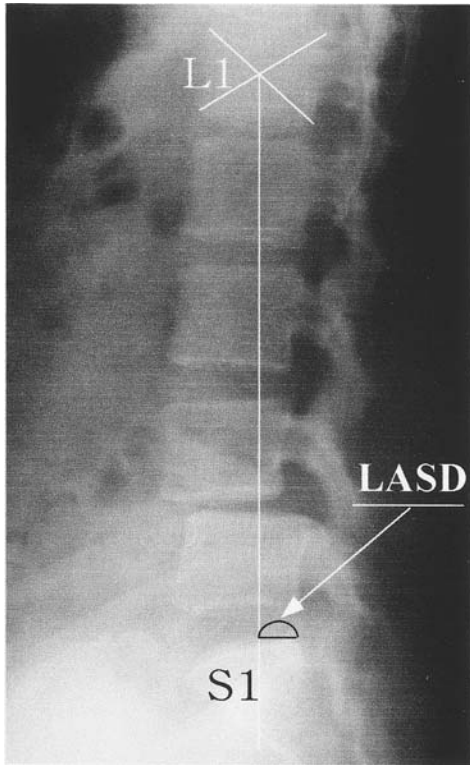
The L1 axis S1 distance (LASD): the horizontal distance from the L1 plumb line to the back corner of the S1 body, as observed on a lateral x-ray taken with the patient in the neutral standing position. (From Refs. 10–13.)
